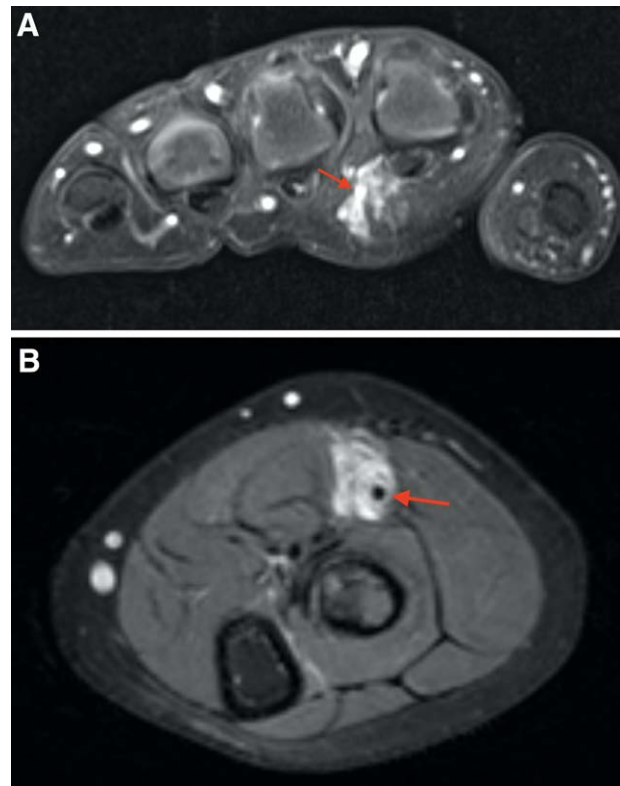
Representative MRI images from two patients in this series. A, A 7-year-old boy with a palmar venous malformation, the most proximal image of which demonstrates the common digital artery entering its mid substance (red arrow). B, A 10-year old girl with a forearm fibro-adipose vascular anomaly surrounding the radiolucent radial artery (red arrow).
